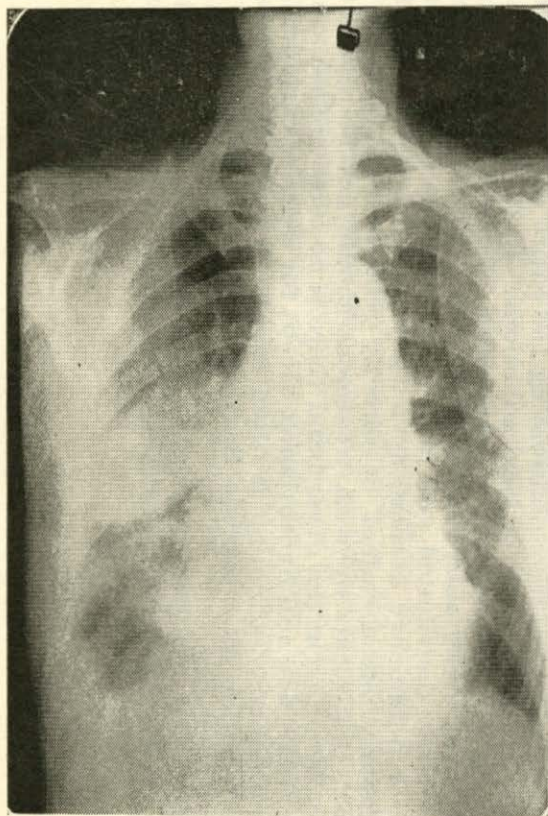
X-ray on 2-2-45 showing interlobar effusion on the right side, also aneurysmatic dilatation of Aorta.
